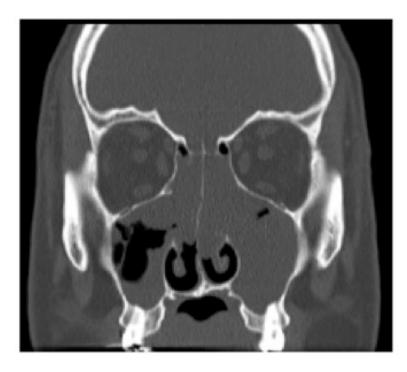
Sinus CT scan of a patient with CRSwNP. Coronal view.
